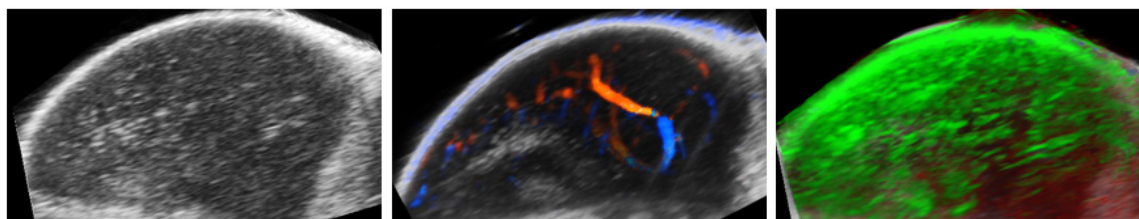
Left to right: Ultrasound *in vivo* imaging, combined ultrasound/Color Doppler imaging and ultrasound/photoacoustic imaging of the Mantle cell lymphoma tumor.
